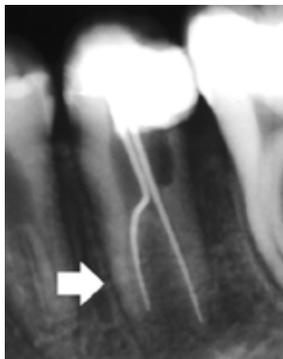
X-ray with gutta percha points in the root canals of tooth 35. The second canal is indicated with a white arrow.
